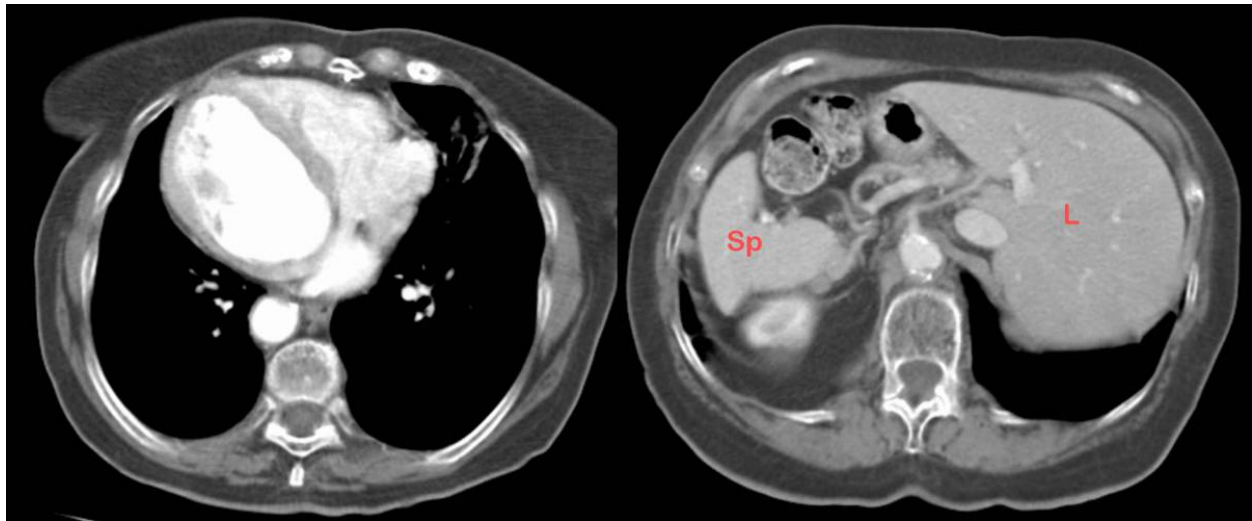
Contrast-enhanced CT scan of the lower chest reveals dextrocardia. Transverse contrast material-enhanced CT scan of the abdomen demonstrates mirror-image location of the abdominal structures relative to situs solitus (normal). The liver (L) is located in the left upper quadrant, whereas the spleen (Sp) is located in the right upper quadrant.
